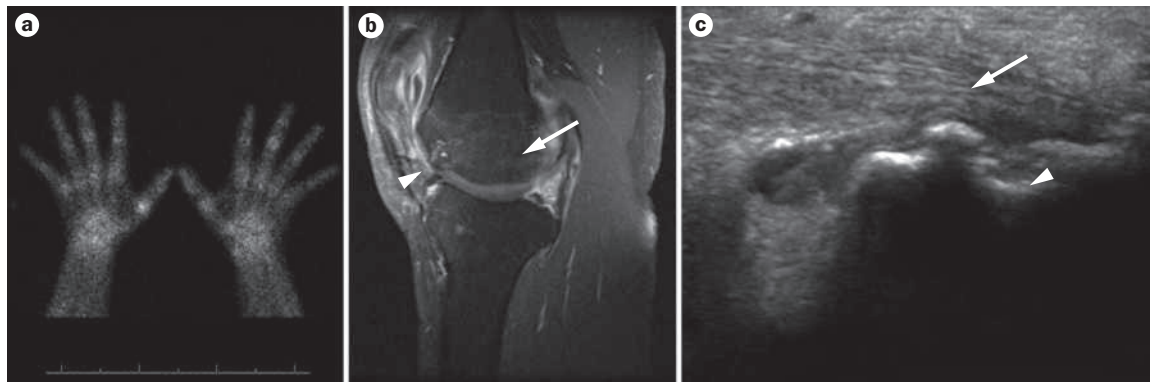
Imaging studies in early psoriatic arthritis. a | Nuclear bone scan showing increased uptake of technetium in the small joints of the hands and carpus, which suggests the presence of articular inflammation, in a patient with psoriasis referred to a rheumatology clinic for back pain. b | MRI of a patient with early psoriatic arthritis (disease duration of 12 months) showing extensive bone marrow edema (arrow) and soft tissue inflammation (arrowhead). c | Ultrasound image of Achilles tendinopathy in a patient with early psoriatic arthritis (joint symptoms duration of 2 months) showing thickening of the Achilles tendon (arrow) and erosions at the enthesitis (arrowhead). Printed with permission from R. Thiele.
